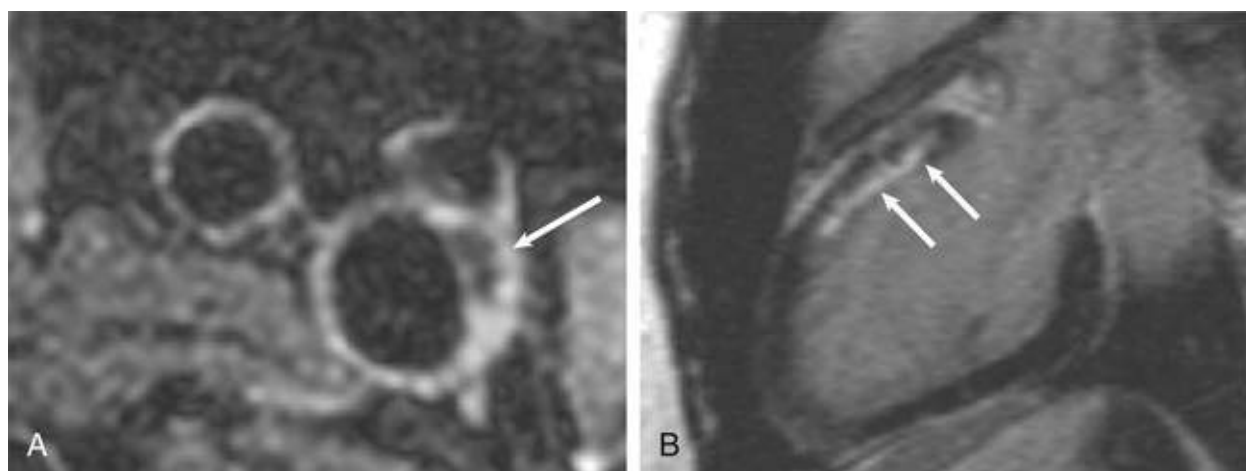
Atherosclerosis in systemic lupus erythematosus. A, Transaxial T2-weighted CMR of the carotid bifurcation showing atherosclerotic plaque (*arrow*). The lipid-filled core and fibrous cap can be seen along with evidence of calcification. B, CMR showing a two-chamber view in the late phase after gadolinium injection. Subendocardial late gadolinium enhancement is present in the anteroseptal left ventricle (*arrows*) and extends from the base of the heart to the midventricular region, consistent with a previous subendocardial myocardial infarction.
